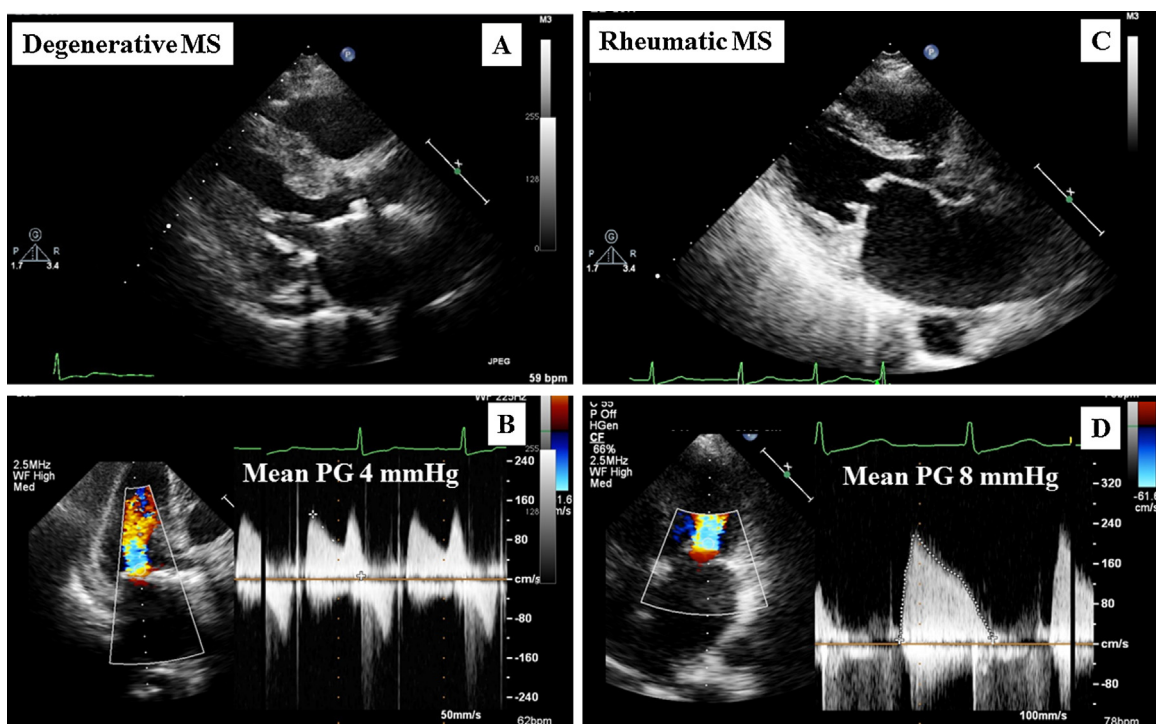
Images of two-dimensional echocardiography and continuous wave Doppler echocardiography in a patient with degenerative mitral stenosis (MS) (left) and a patient with rheumatic MS (right). PG, pressure gradient.
